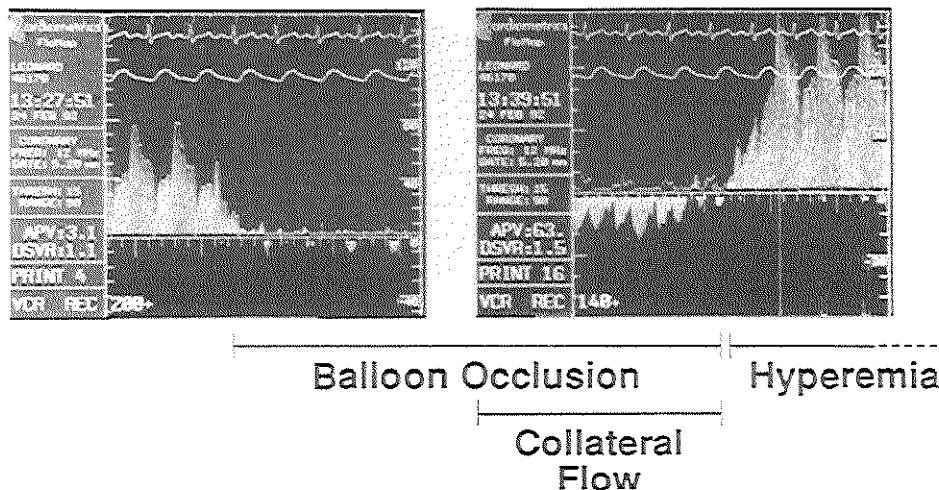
Spectral velocity (scale 0 to 200 cm/sec) showing normal antegrade (upward directed from base) flow pattern with phasic systolic and diastolic flow prior to coronary balloon occlusion. At balloon occlusion, coronary flow goes to zero. After 10 seconds, collateral flow appears as reversed flow toward the guidewire tip (inverted phasic signal beneath the baseline). On balloon deflation, antegrade flow is restored with posts ischemic hyperemia. During balloon occlusion, the collateral flow velocity can be quantitated. (From Kern MJ, Donohue TJ, Bach RG, et al: Quantitating coronary collateral flow velocity in patients during coronary angioplasty using a Doppler guidewire. *Am J Cardiol* 17:34D-40D, 1993.)
